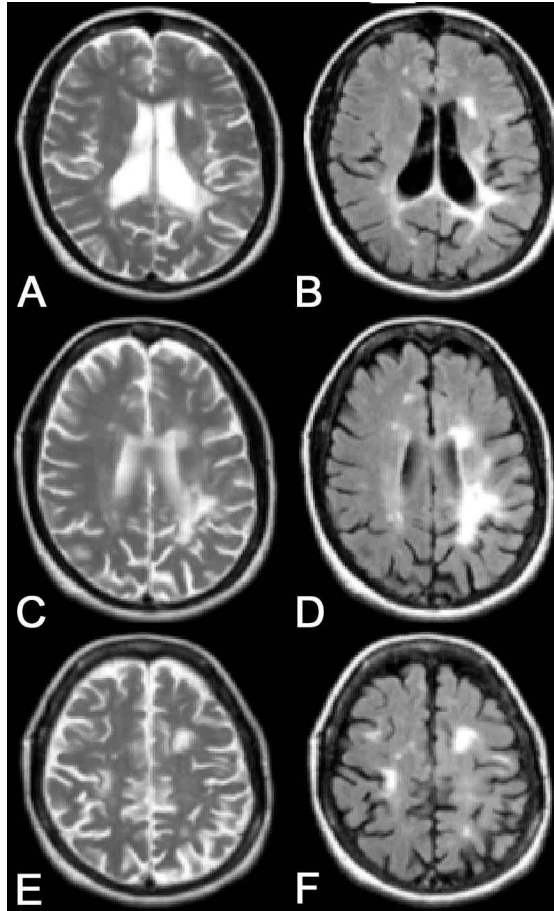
Axial FSE T2-WI (a,c,e) and FLAIR images (b,d,f) in a 27-year old woman with RR MS show typical hyperintense periventricular lesions (a-d) and also involvement of the cortical/juxtacortical region (e,f). FLAIR is superior to T2-WI in the detection of periventricular (b,d) and cortical/juxtacortical lesions (f) because of the heavier T2 weighting combined with the suppression of CSF.
